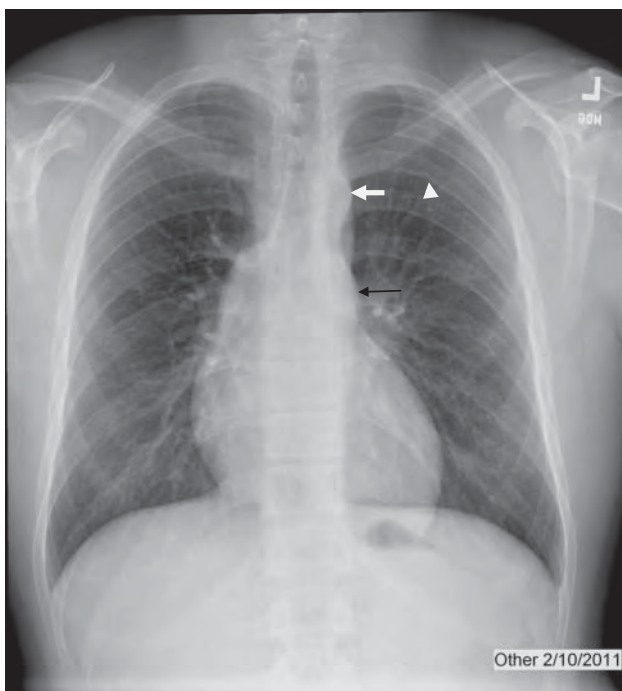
Frontal radiograph of the chest in a patient with high blood pressure in the upper extremity shows a classic “figure 3” sign from dilatation of the left subclavian artery (white arrow) and post-stenotic dilatation of the proximal descending thoracic aorta (black arrow) in a patient with coarctation. Subtle sclerosis and undulation of the inferior surface of the ribs is seen consistent with rib notching from prominent arterial collaterals (arrowhead).
